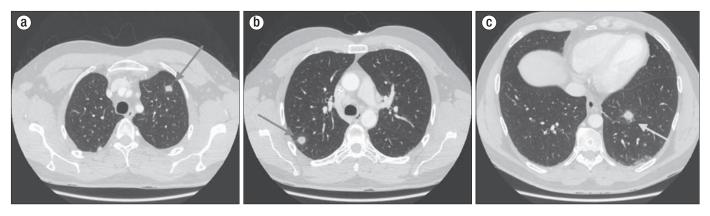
Cross-sectional CT shows pulmonary nodules (arrows) in the (a) left upper lobe measuring 1 cm, (b) right upper lobe measuring 1.3 cm, and (c) left lower lobe measuring 1.6 cm.
